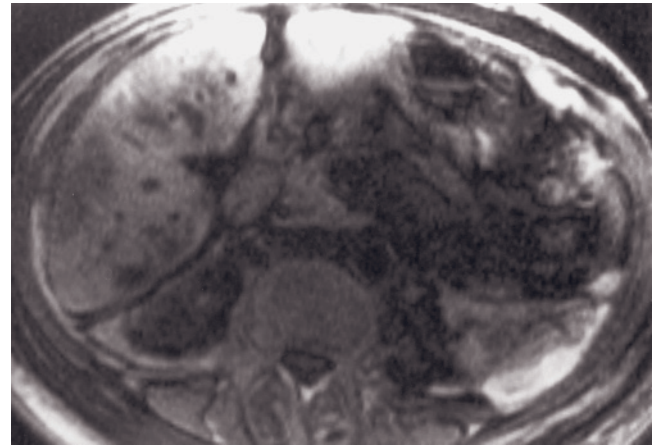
Arterial ischemia. T2-weighted fat-suppressed ETSE (a), SS ETSE (b), SGE (c), and immediate (d) postgadolinium SGE images. The liver is enlarged with diffuse increased signal intensity on T2-weighted images (a), consistent with edema. There is a 2-cm focus in the right hepatic lobe and an irregular hepatic central region that demonstrate decreased signal intensity on both T2-weighted (a) and T1-weighted (b) images, most pronounced on T2, and negligible enhancement on early (d) postgadolinium images. These features are consistent with arterial ischemia.
